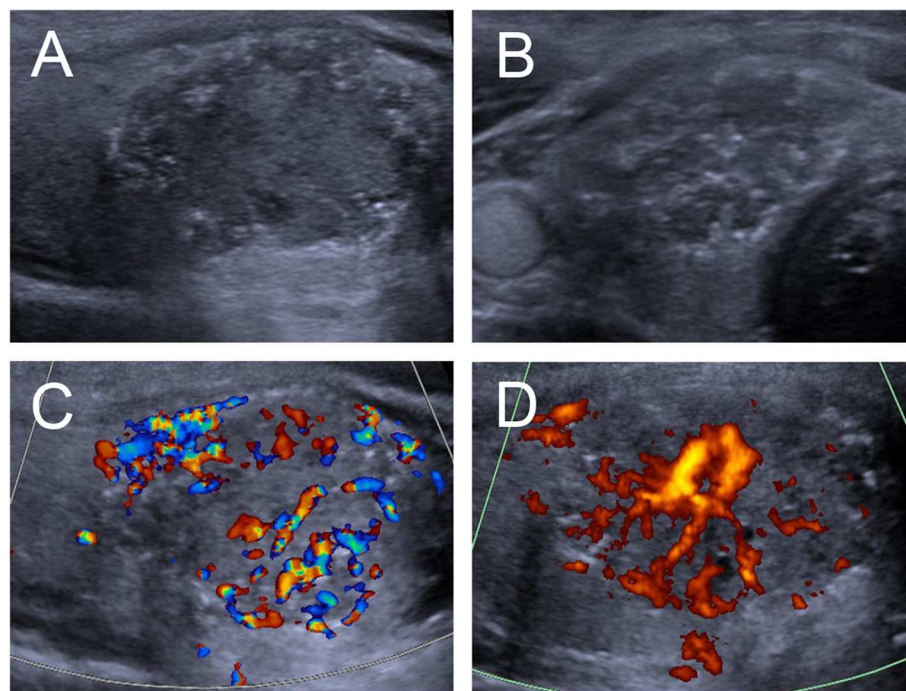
Ultrasound images of an 18-y-old female PTC patient with petal-like calcification of the right thyroid lobe. (A) Longitudinal and (B) Horizontal gray-scale sonograms; the thyroid nodules had a solid component, hypoechoic echogenicity, and ill-defined margin. (C) Color Doppler and (D) Energy Doppler sonograms showed abundant internal and peripheral vascularities.
